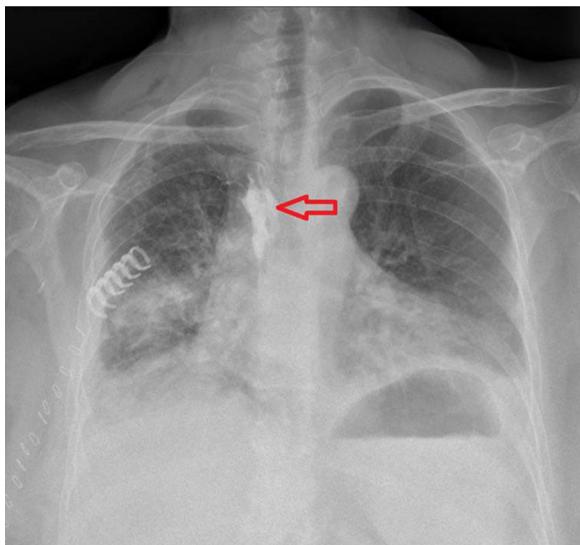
Posteroanterior chest radiography: paravertebral diffusion of iodinated contrast agent at the level of the third to the fifth intercostal space, administered through the catheter (arrow).
